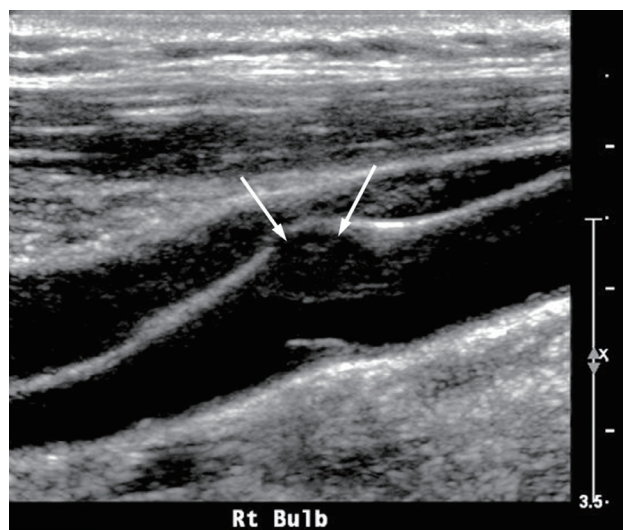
Ultrasound (US) example of an echolucent plaque. The US image shows a smooth echolucent plaque (arrows) on the carotid wall.
